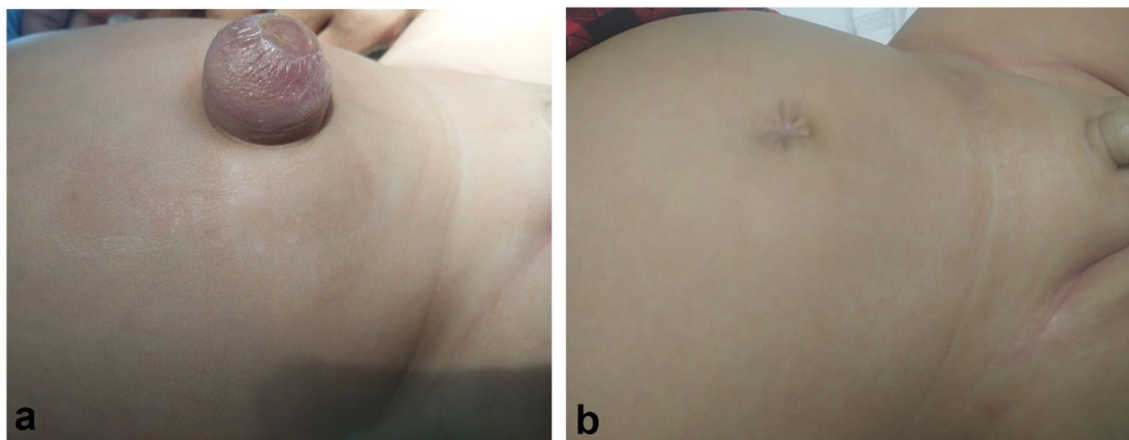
One-month-old baby boy with left inguinal hernia (CAT1) and large umbilical hernia. Left FLAIR and Umbilicoplasty were performed under the same general anesthesia. a Preoperative picture. b Scars after 5 months
